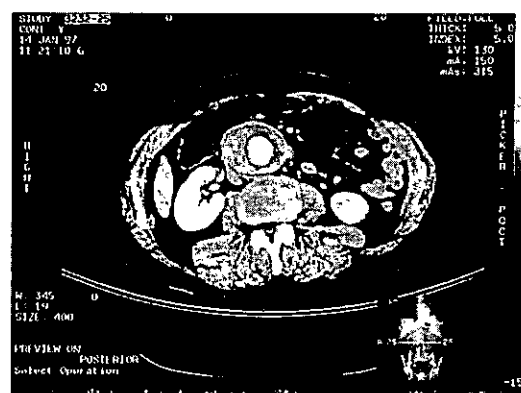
CT scan of a patient with an IAAA related with aortitis. The peri-aneurysmal fibrosis involves also the posterior segment.
